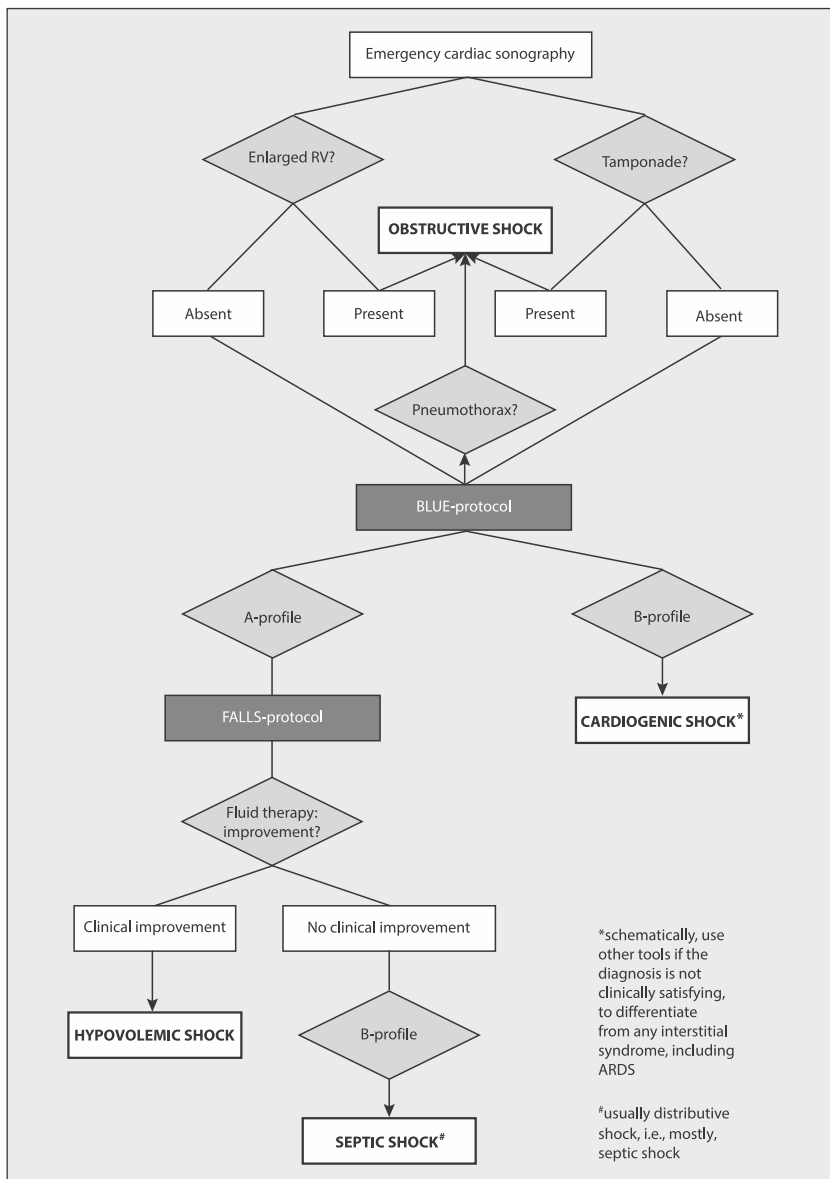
The FALLS protocol. A decision tree facilitating the understanding of the FALLS protocol. According to the Weil classification, cardiac and lung ultrasound sequentially rule out obstructive, cardiogenic (from left heart), hypovolemic and finally distributive shock, i.e. septic shock in current practice. Adapted from [34]. FALLS protocol = Fluid Administration Limited by Lung Sonography; BLUE protocol = Bedside Lung Ultrasound in Emergency; RV = right ventricle
